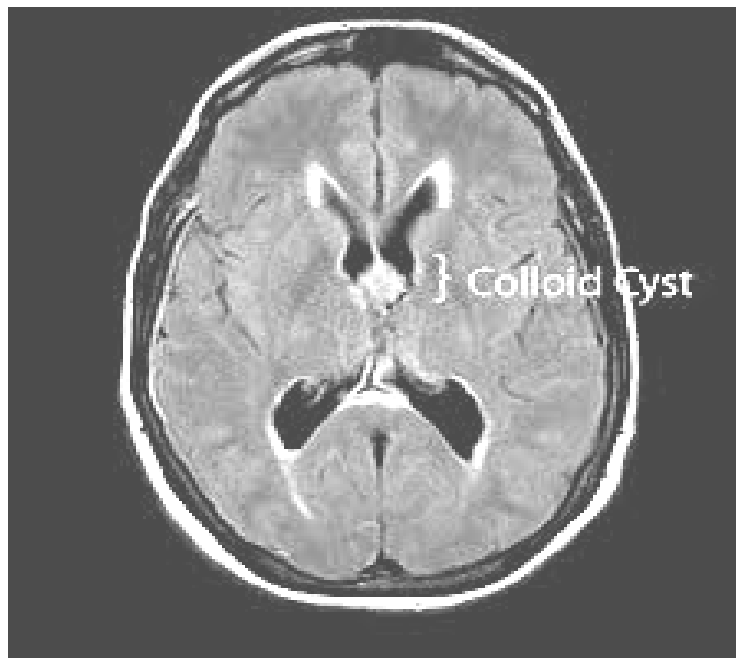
axial MRI image show Colloid Cyst
